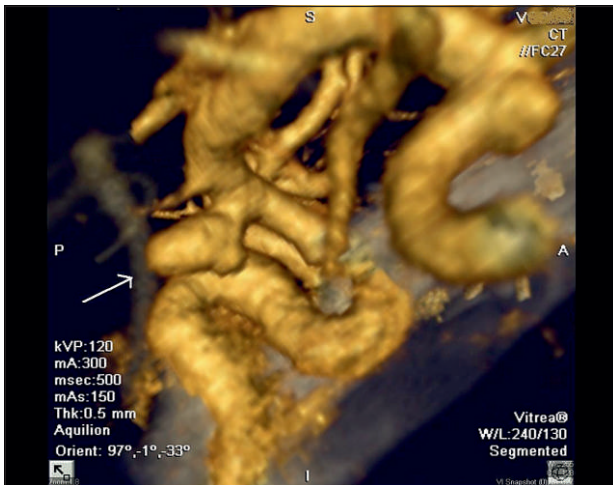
CTA shows right side aneurysm of ICA, 14 mm in diameter (arrow).
